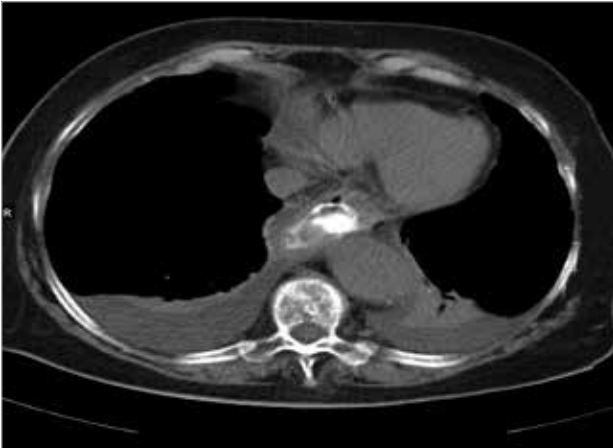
Control chest computed tomography scan, with normal esophageal lumen appearance
